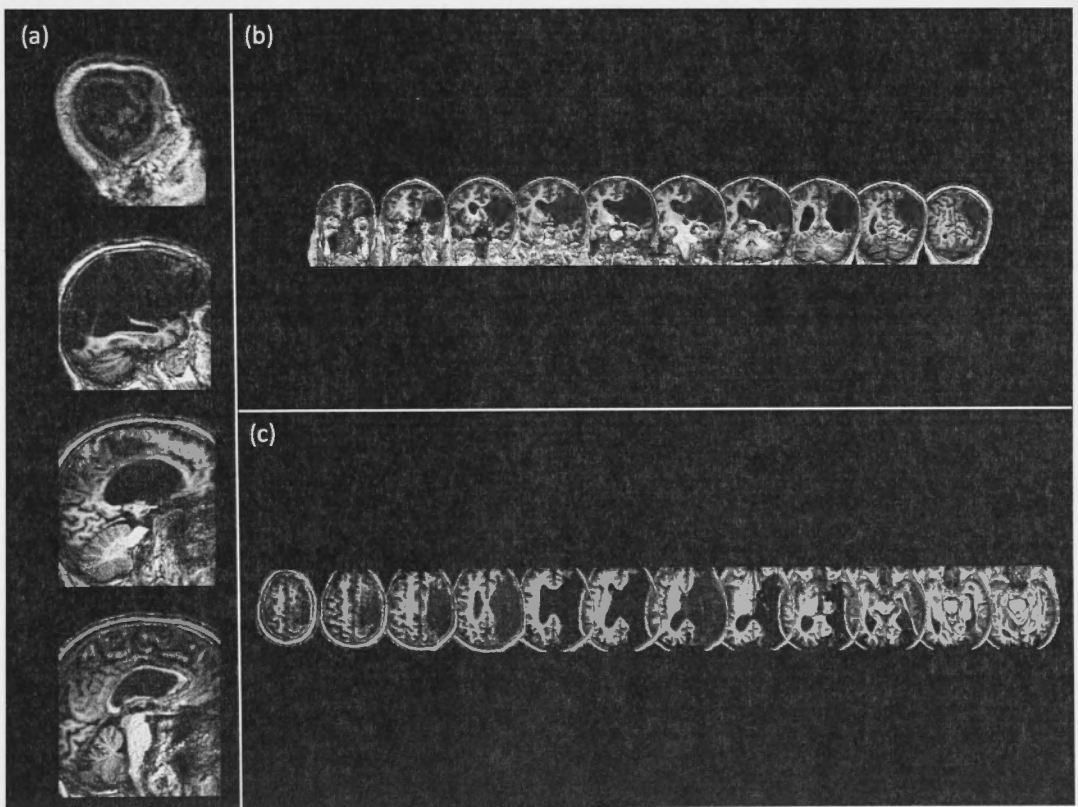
T1-weighted brain MR images of patient HH:
